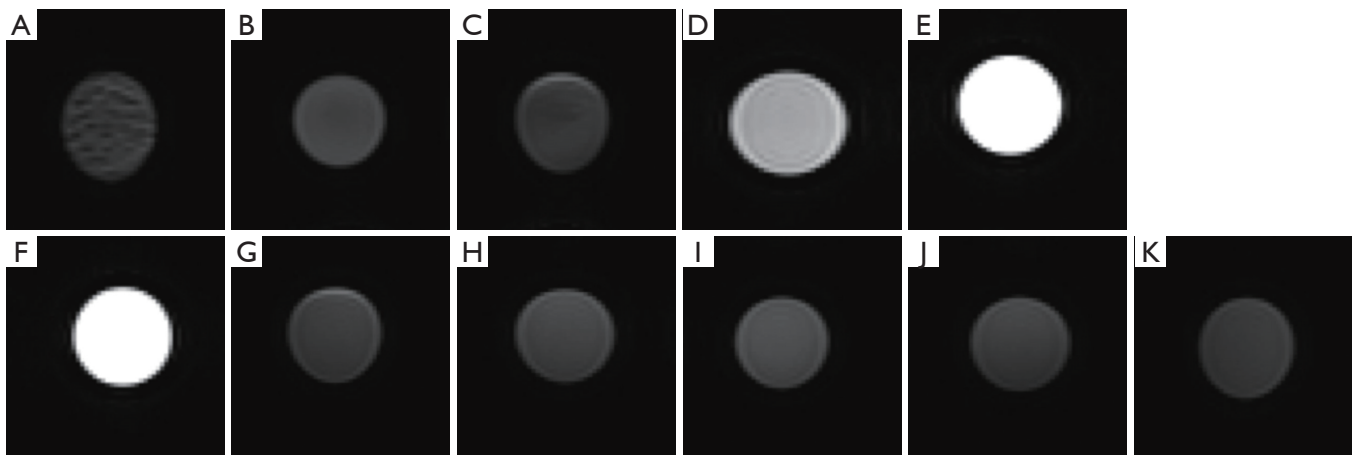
T1-weighted images. (A) Silicone rubber; (B) silicone rubber with fish oil; (C) fresh silicone rubber; (D) silicone oil with a viscosity of 50 mm²/s; (E) peanut oil (Basoo); (F) peanut oil (Pressed Purity); (G) agarose gel 0.5 wt%; (H) agarose gel 1.0 wt%; (I) agarose gel 1.5 wt%; (J) agarose gel 2.0 wt%; (K) agarose gel 2.5 wt%.
